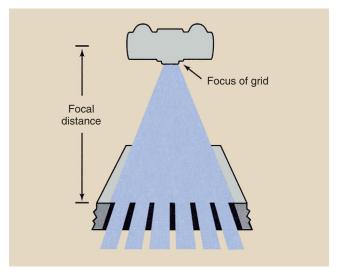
A focused grid is fabricated so that grid strips are parallel to the primary x-ray path across the entire image receptor.
